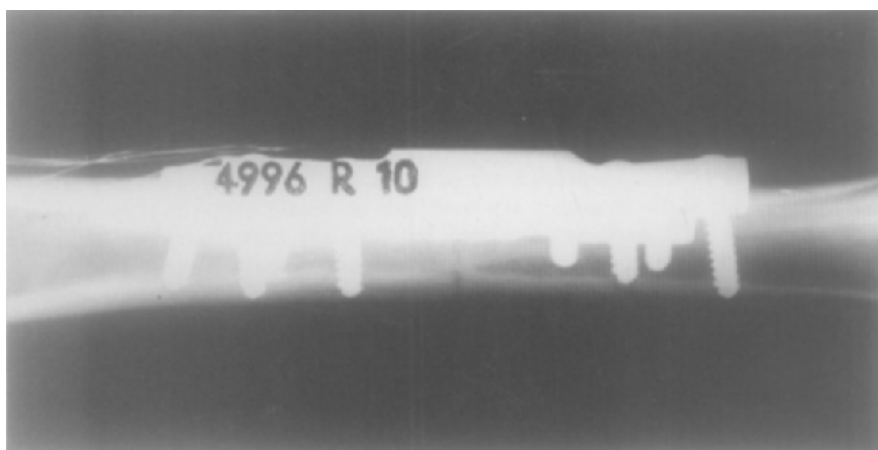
X-ray taken at 10 weeks after operation. In spite of full weight-bearing very little callus can be seen. Bony union has occurred.
